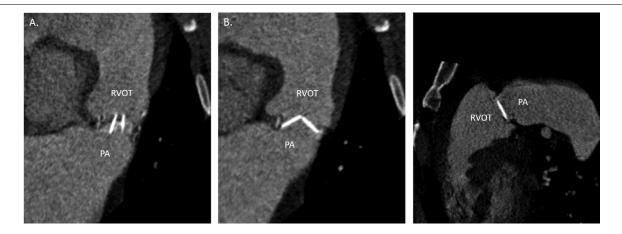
Computed tomographic multiplanar reformats of mechanical pulmonic valve after thrombolysis. Long axis during systole (A) and diastole (B and C) demonstrating improved leaflet motion.
